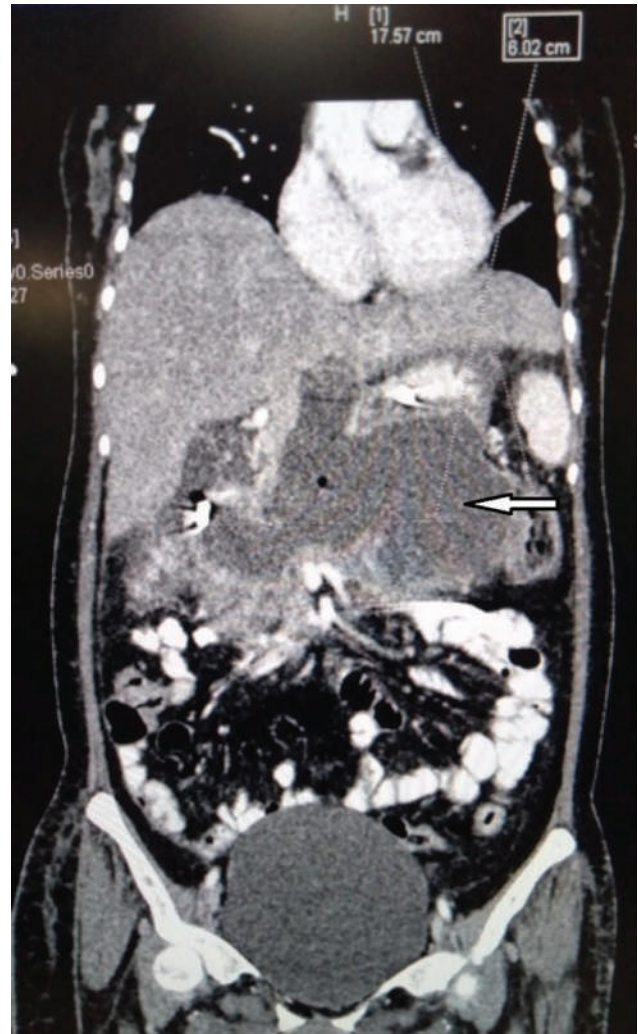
Contrast-enhanced CT scan of the abdomen showing pseudocyst of the pancreas (arrow) compressing the stomach.
